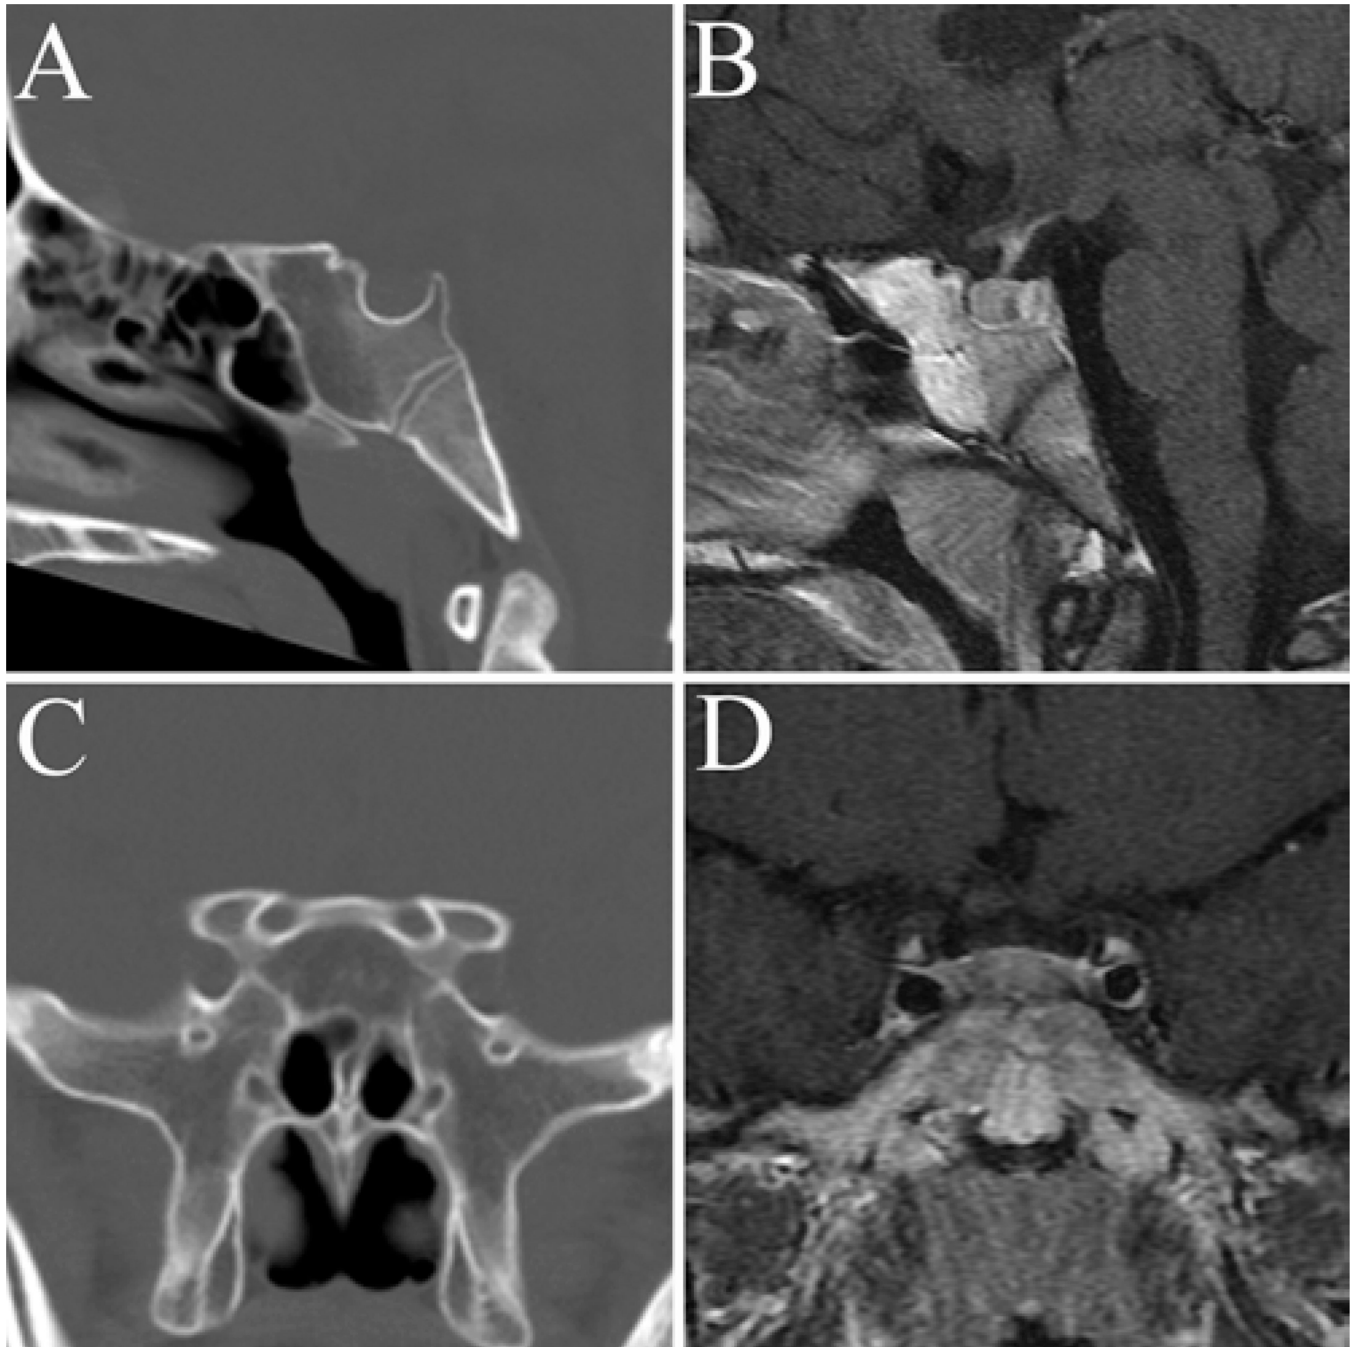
Sagittal (A and B) and coronal (C and D) CT (A and C) and MR (B and D) images showing an example of a “conchal,” or nonpneumatized, sphenoid sinus. This variation was identified in 1% of normal subjects and in no patients with sellar tumors.
